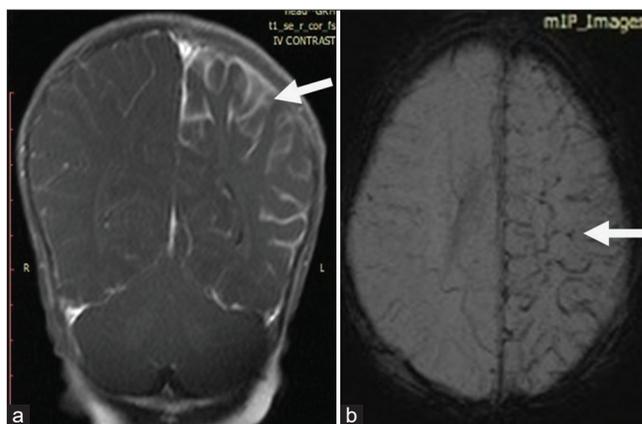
(a) Magnetic resonance imaging brain T1 contrast coronal cut showing pial enhancement in temporoparietal region. (b) Magnetic resonance imaging brain SWI film showing trans parenchymal medullary veins connecting subependymal vein with cortical veins
